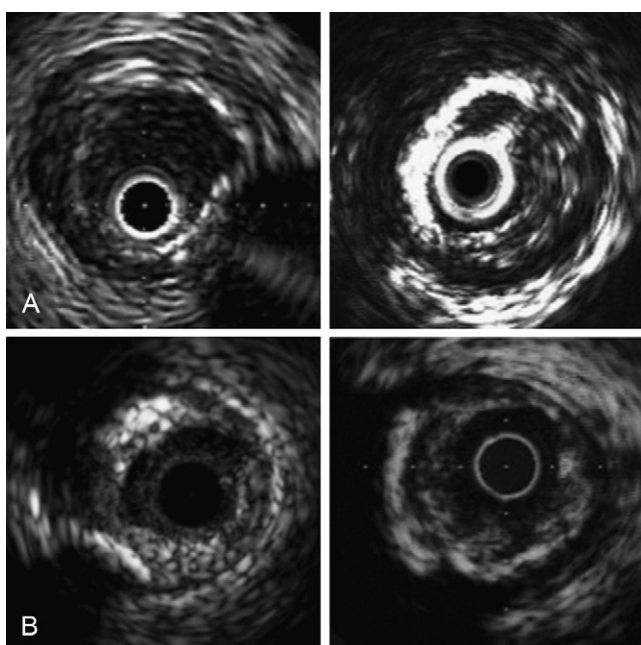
Intravascular ultrasound images for various types of coronary arterial disease. A, Normal vessel. B, Mild atherosclerosis. (Courtesy of John M. Hodgson, MD.)
